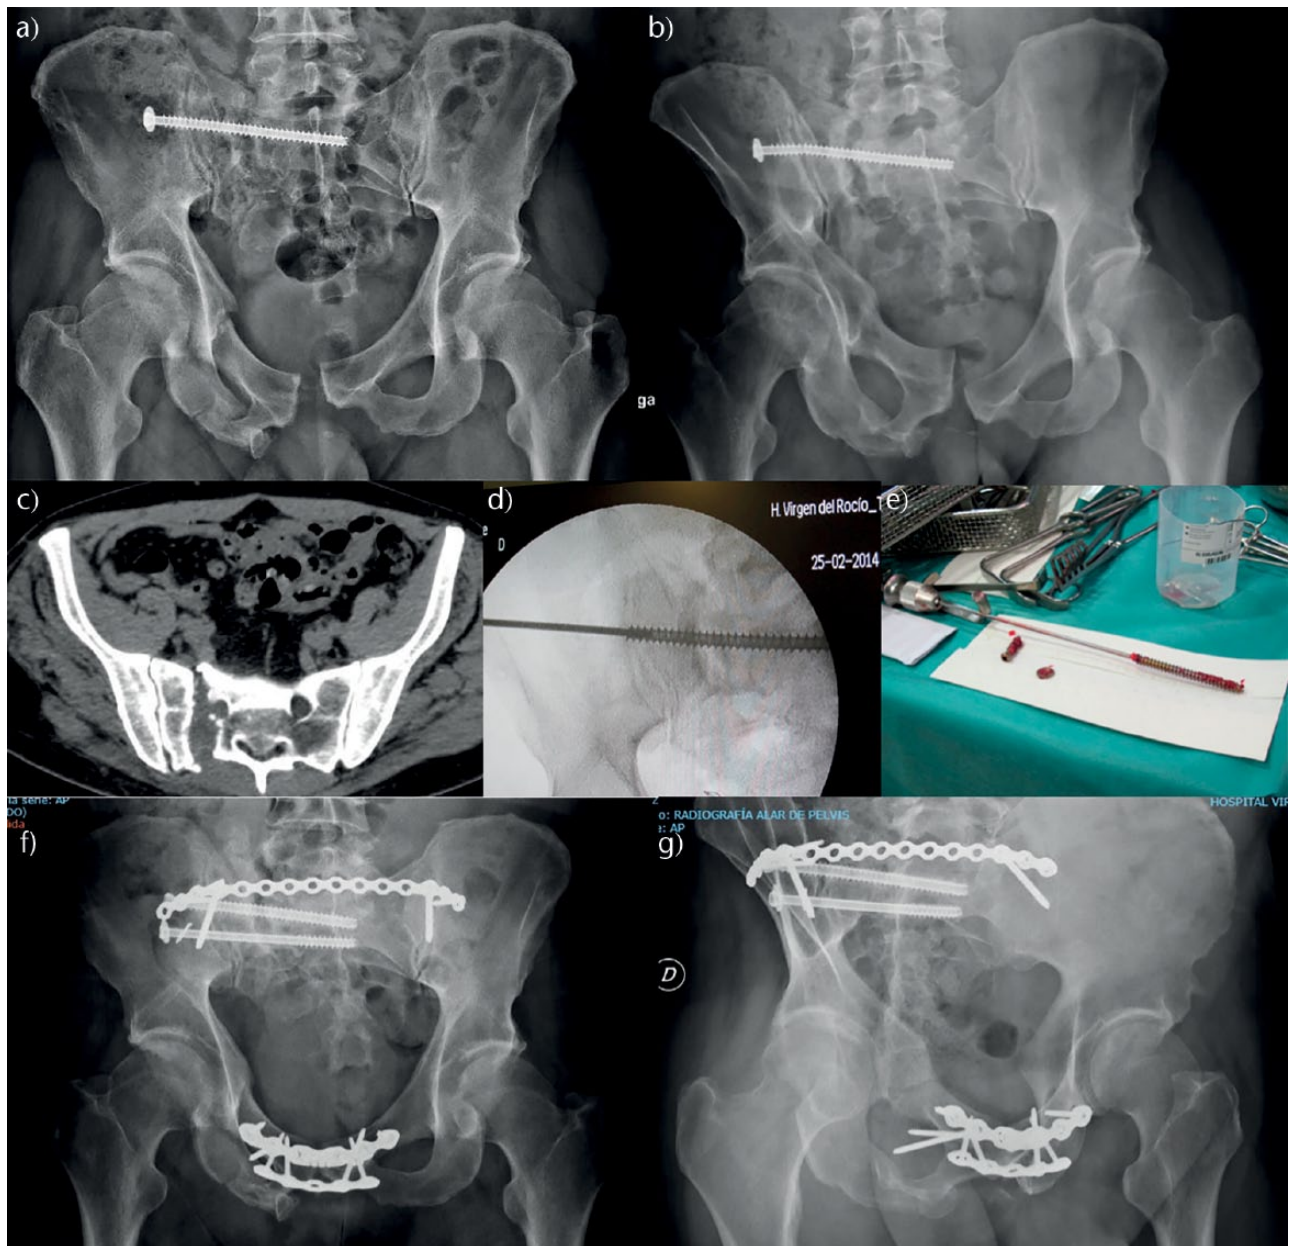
Type III combined residual instability of vertical predominance: a) and b) preoperative radiograph; c) preoperative CT scan (axial view) showing sacral fracture nonunion; d) and e) technique to retrieve the broken sacro-iliac screw; f) and g) radiograph control after nine years of follow-up.
